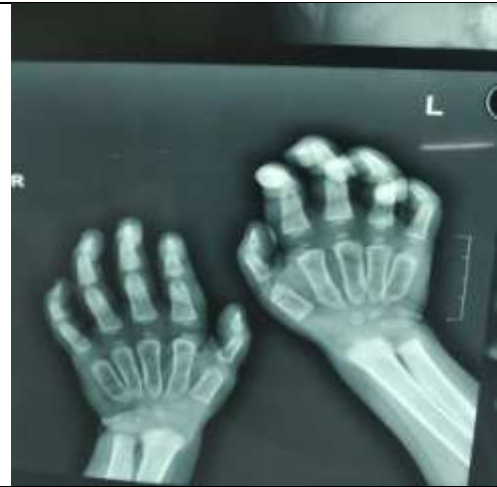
2 the hand radiograph shows proximal pointing metacarpals.
